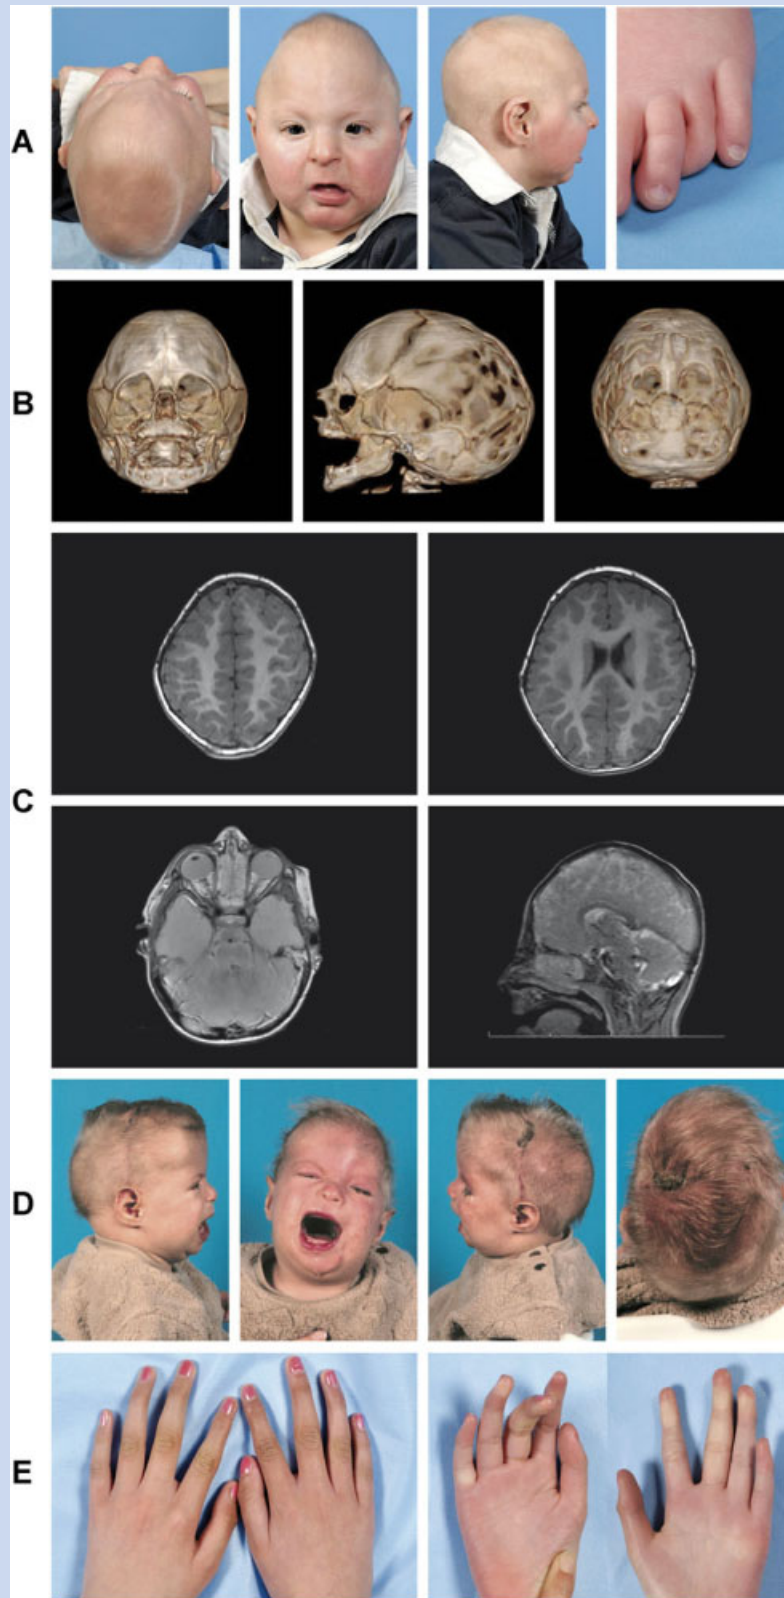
Clinical data of Patients 1 and 2. A: Patient 1 at the age of six months. Note the trigonocephalic form of the skull and the small size of the head, the strabismus and epicanthal folds on both eyes and clinodactyly of the fourth ray on the feet. B: Three-dimensional CT scan of patient 1 at the age of 3 months showing a synostosis of the metopic and sagittal suture, hypotelorism and impressions at the occipital and parietal bones. C: MRI of Patient 1 at the age of 2 years and 10 months shows a simplified gyral pattern in the supra tentorial region and a hypoplastic corpus callosum. The cerebellum and pons are rather small. D: Patient 2 at the age of 6 months. Note the abnormal skull shape and small size of the head, a very broad nasal root and a flat philtrum, blepharophimosis, long eyelashes, and an expired helix fold of the ears. E: Hands of Patient 2 at the age of 12 years. Tapering of the fingers is clearly seen (in the dorsal view) as is the campodactyly of the third and fourth ray on the hands.
